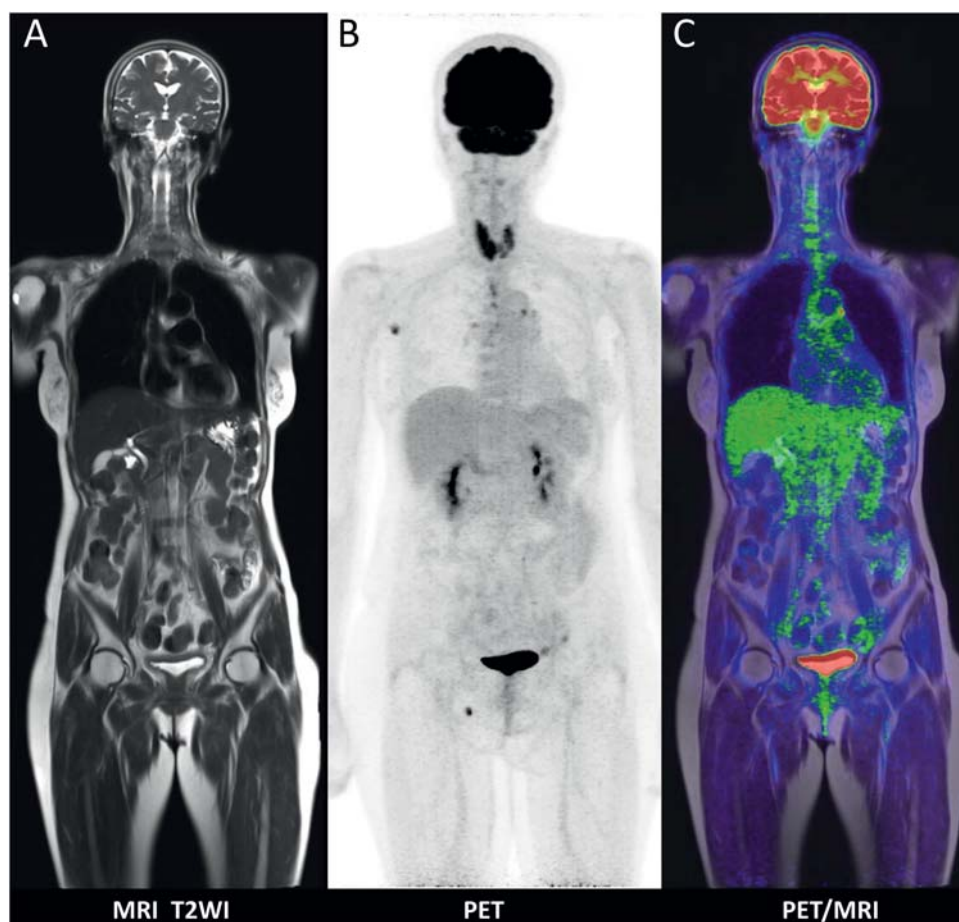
Whole-body layout for integrated PET/MRI scanning. (A) Coronal plane of fast T2-weighted MRI, from skull to mid-thigh. (B) Coronal maximum intensity projection of a PET image. (C) Registration of integrated whole-body PET and MRI.
